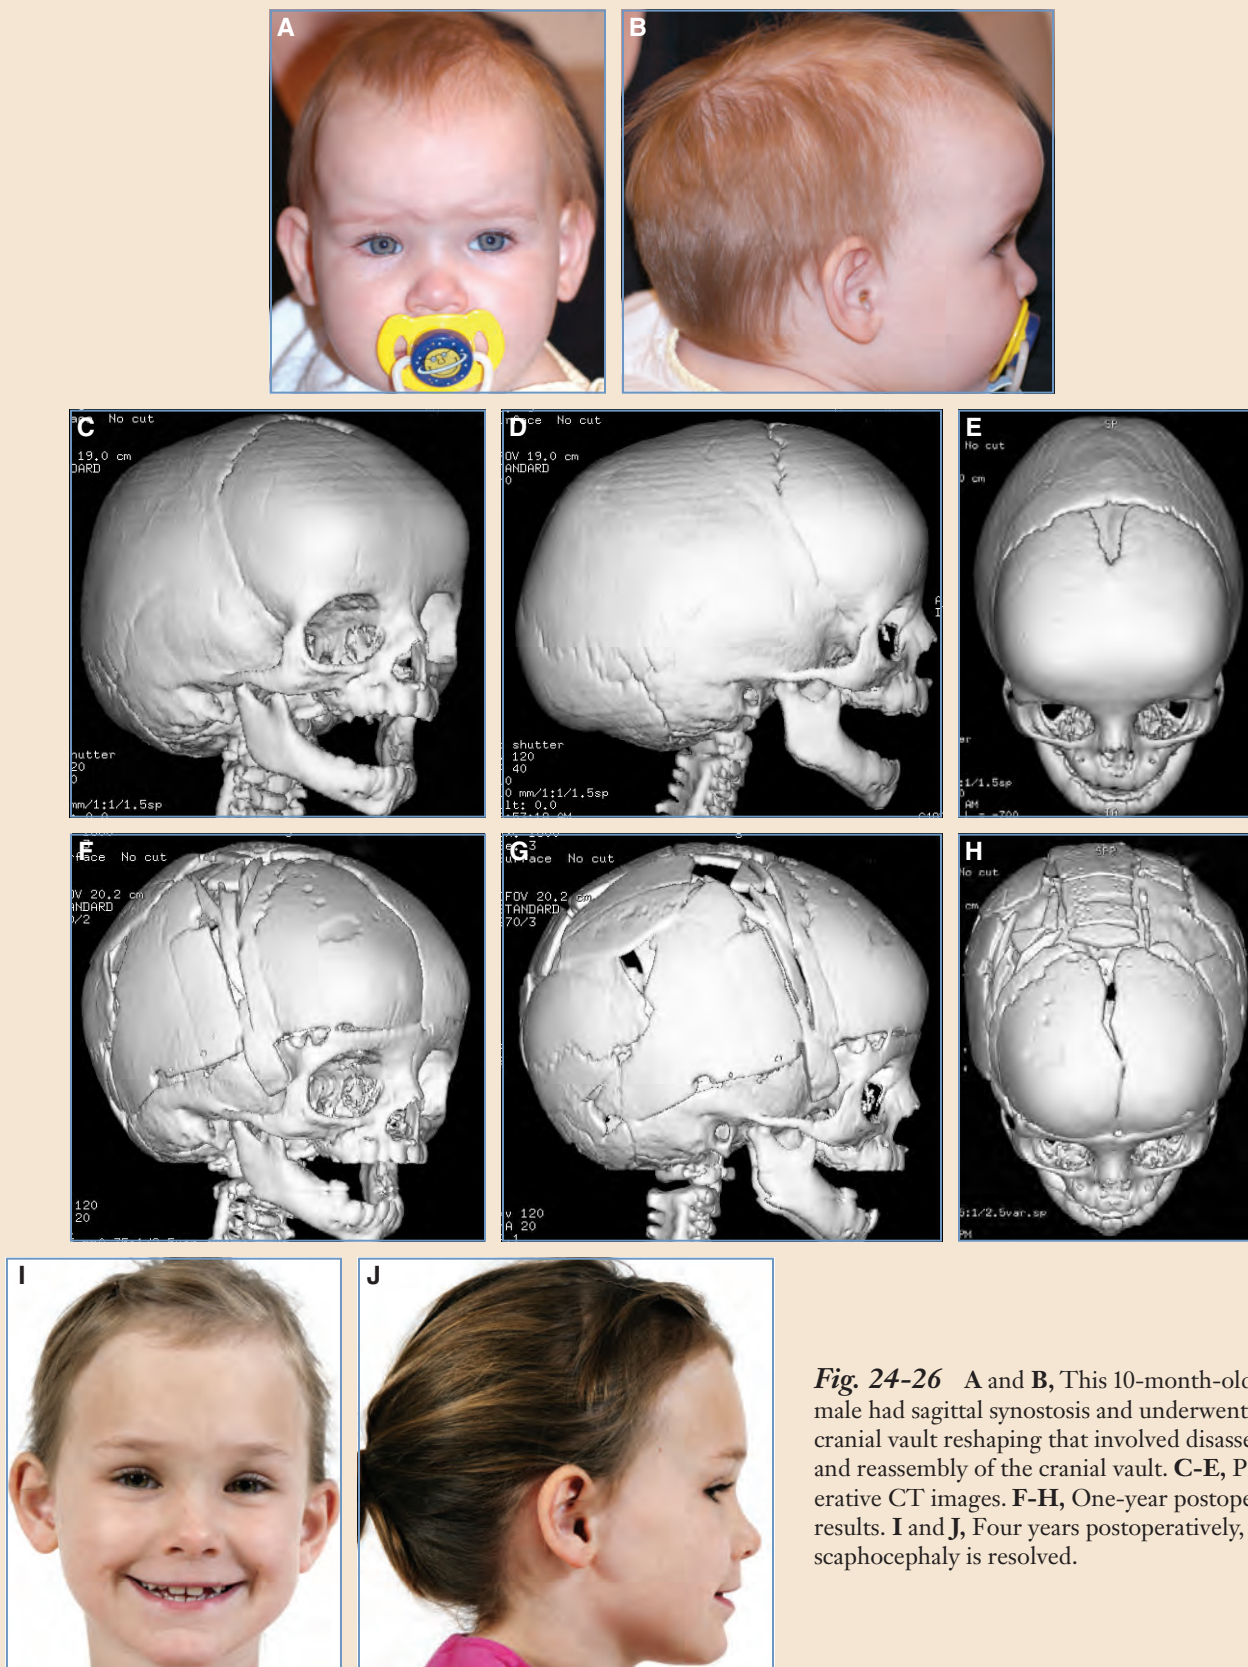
A and B, This 10-month-old female had sagittal synostosis and underwent a total cranial vault reshaping that involved disassembly and reassembly of the cranial vault. C-E, Preoperative CT images. F-H, One-year postoperative results. I and J, Four years postoperatively, her scaphocephaly is resolved.
